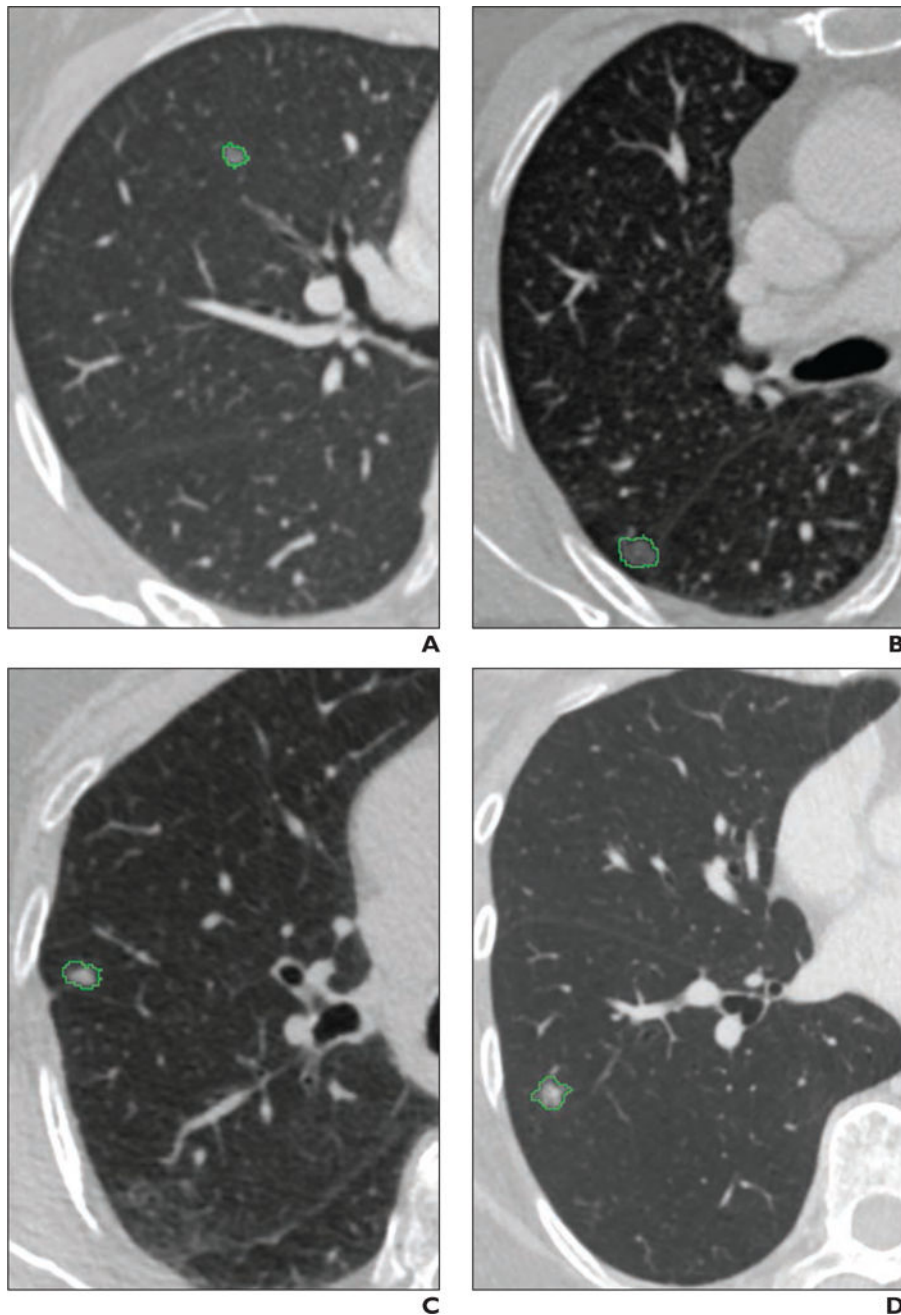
Preoperative CT scans of four types of ground-glass opacity nodules (GGNs). GGNs have been segmented on CT images. Segmentation outline is shown in green. A–D, CT scans show atypical adenomatous hyperplasia (A), adenocarcinoma in situ (B), minimally invasive adenocarcinoma (C), and invasive adenocarcinoma (D).
